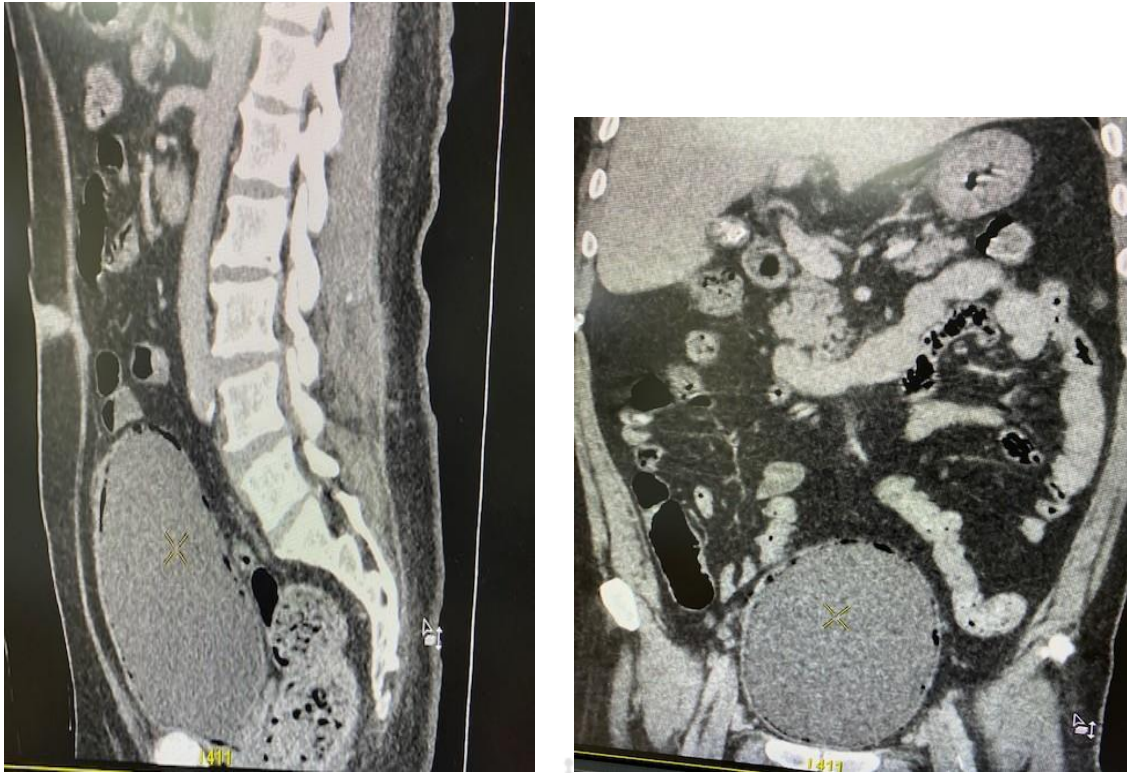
Figure A -Sagittal CT Scan Figure B- Coronal CT scan
